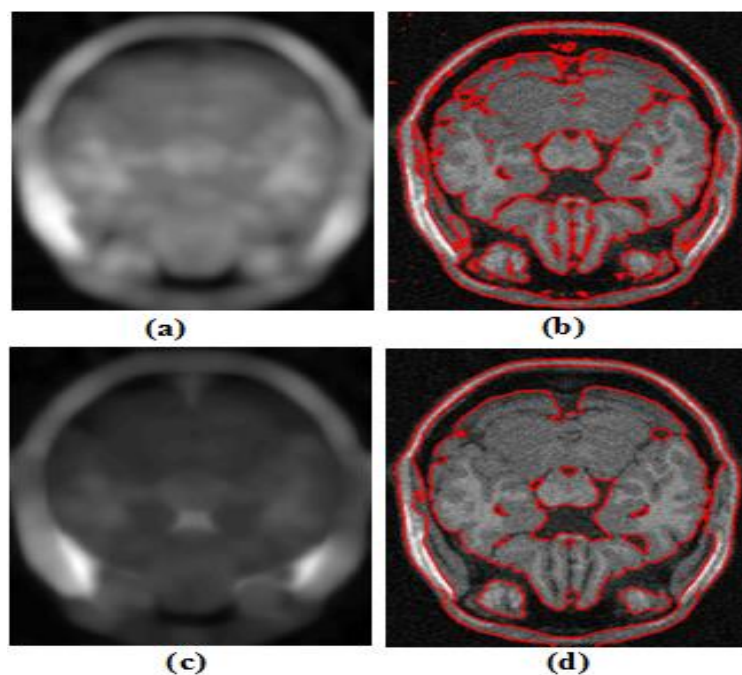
On a noisy MRI image (a, b) Bias field & final contour using W. Cui et al method (c, d) Bias field & final contour using the proposed method
